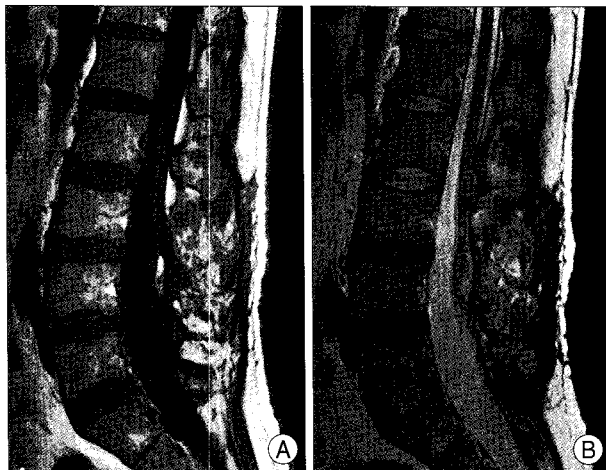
Postoperative magnetic resonance imaging. T1-weighted (A) and T2-weighted (B) sagittal images reveals no abnormal signals in the conus medullary area from the L2 to L4 level.
